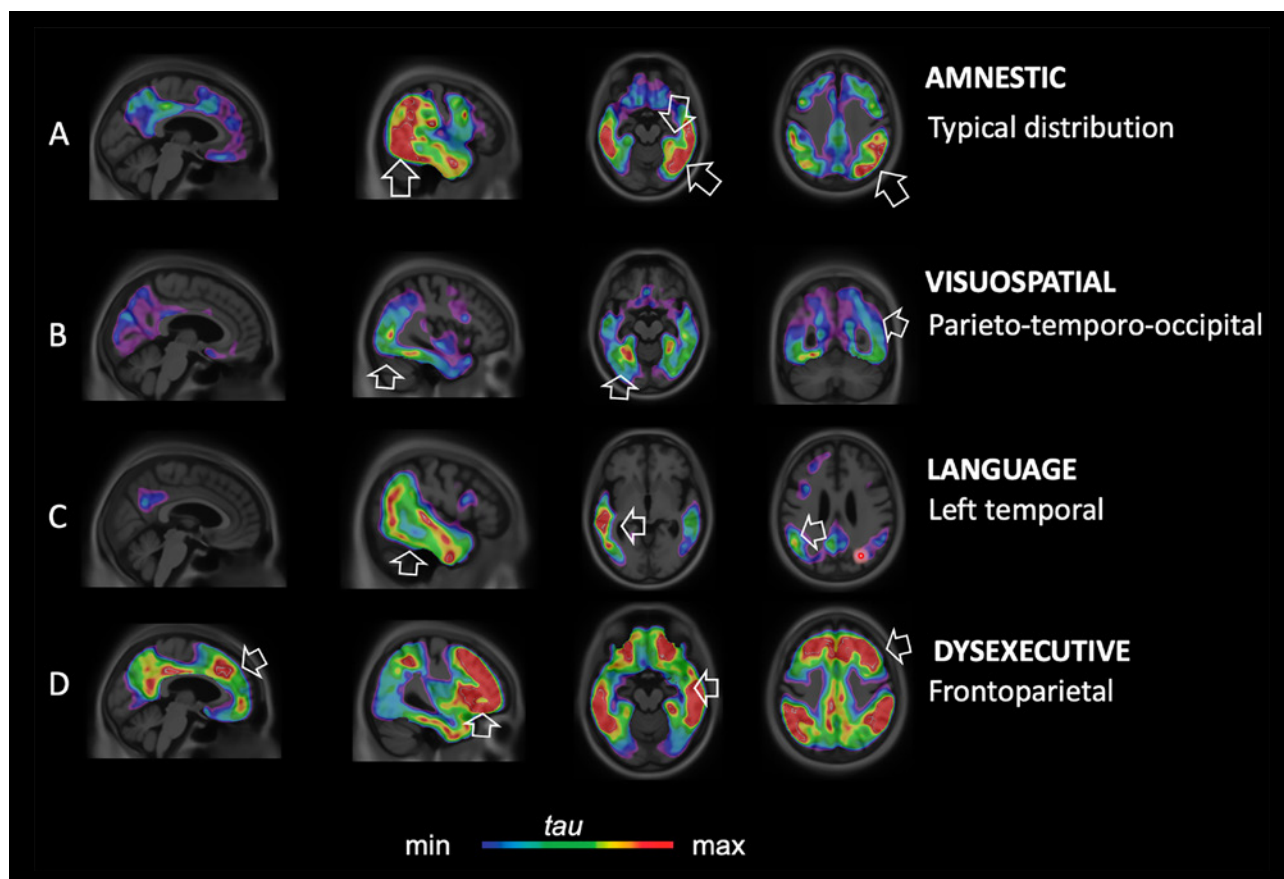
These images represent the distribution of neurofibrillary tangles (rainbow colour) overlaid in a structural MRI (grey tone). The amnesic type of Alzheimer's disease (A) shows tau deposition in the trans and entorhinal areas, limbic cortices, associative neocortex and in the most advanced cases in the primary sensory areas. Note that in visuospatial (B), language (C) and dysexecutive variants of Alzheimer's disease (D) neurofibrillary tangles accumulate in the parieto-temporo-occipital, left temporoparietal and frontoparietal regions, respectively (12, 13).
